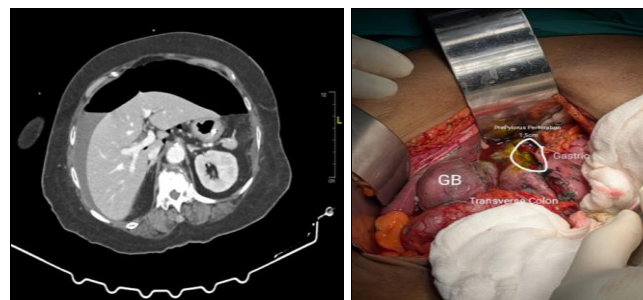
CT images showing massive pneumoperitoneum and intraoperative finding of pre pyloric perforation
